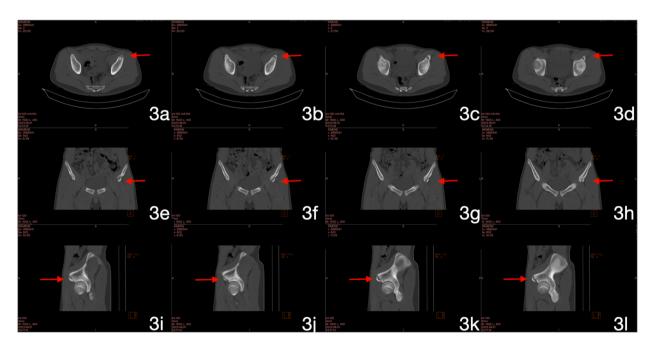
Immediate post-traumatic CT examination, these abnormalities observed on the left side were marked in red on the ultrasound images and the AIIS injury is marked by a red arrow. a-d) Axial CT slices demonstrating fracture fragments located less than 1 cm from the ilium. e-i) Coronal CT slices showing the convergence of the anterior inferior iliac spine (AIIS) and anterior superior iliac spine (ASIS). h-l) Sagittal CT slices revealing the convergence of AIIS and ASIS.
